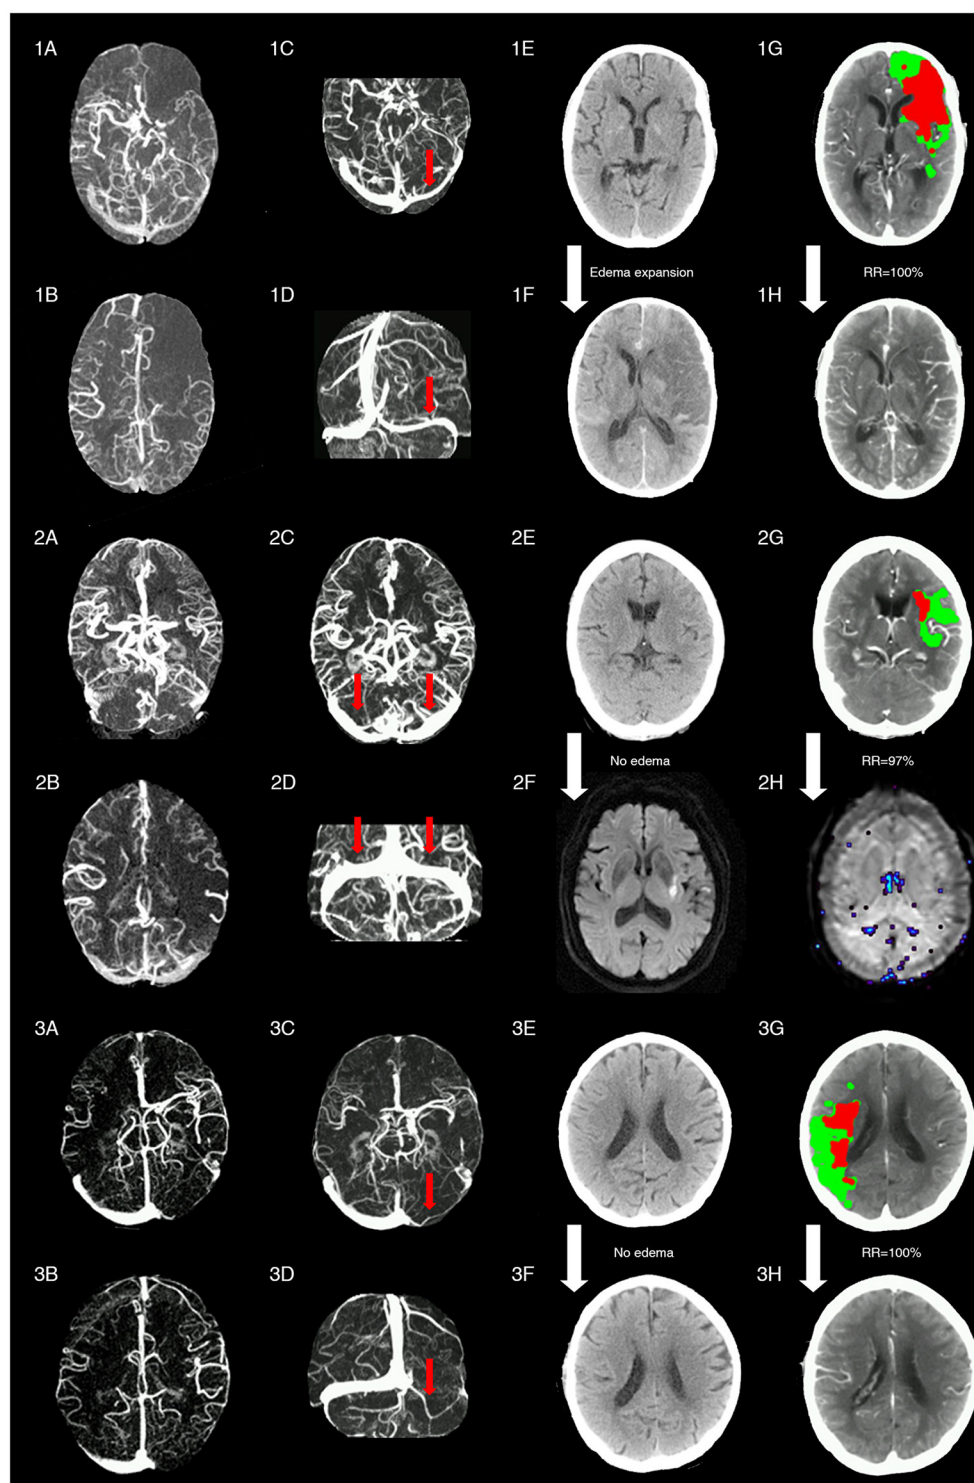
Representative images of patients with different status of ipsilateral transverse sinus and collaterals. Patient 1 with acute left middle cerebral artery occlusion (MCAO) (baseline NIHSS = 14) presented with poor collaterals [integrated collateral grading scale (CGS) = 0] (1A,1B) and FDITS (the red arrow in 1C,1D) on 4-dimensional computed tomographic angiography (4D-CTA). The patient received intravenous thrombolysis bridging with endovascular therapy at 2.5 h from stroke onset. At 24 h after reperfusion therapy, this patient developed brain edema expansion on non-contrast CT (NCCT) from baseline score 0 (1E) to 2 (1F), although reperfusion rate was 100% with hypoperfusion (red plus green area) volume changing from 220 ml (1G) to 0 ml (1H) on lesion map. The modified Rankin scale (mRS) score was 4 at 3 months. Patient 2 with acute left MCAO (baseline NIHSS = 13), presented with good collaterals (CGS = 2) (2A,2B) and symmetric bilateral transverse sinuses (non-FDITS) (two red arrows in 2C,2D) on 4D-CTA. The patient received intravenous thrombolysis at 4 h from stroke onset. At 24 h after
